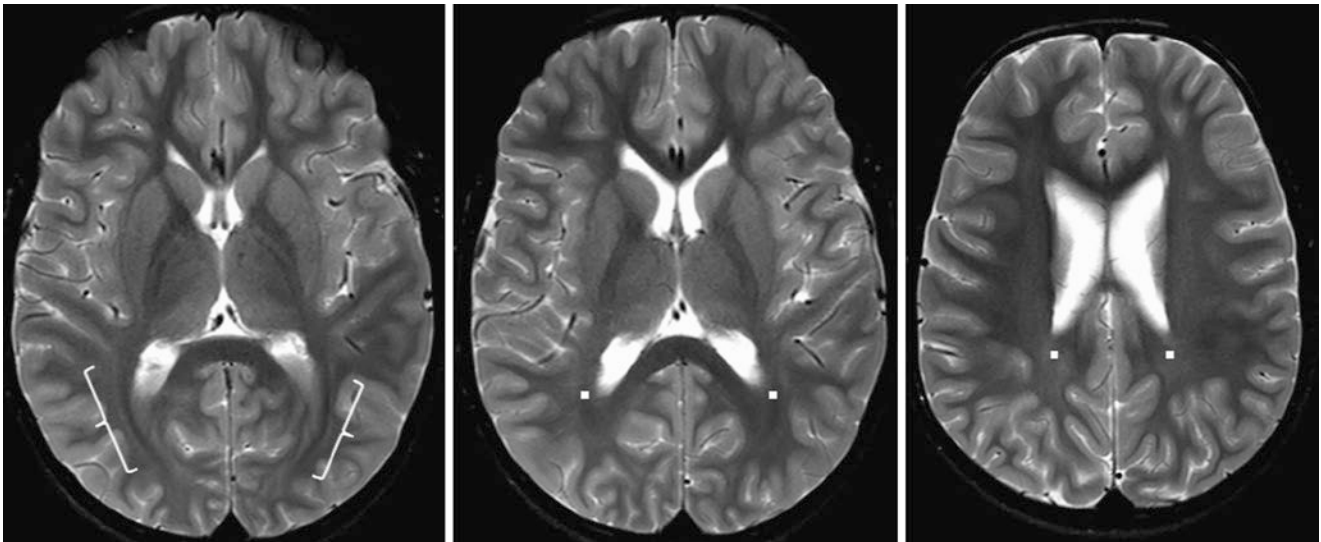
A 9.5-year-old with a developmental delay had a normal 3T MRI. Axial SE T2WIs demonstrate faint, residual terminal zones within the optic radiations (*brackets*) and PTWM (*squares*), which appear to be contiguous with each other
